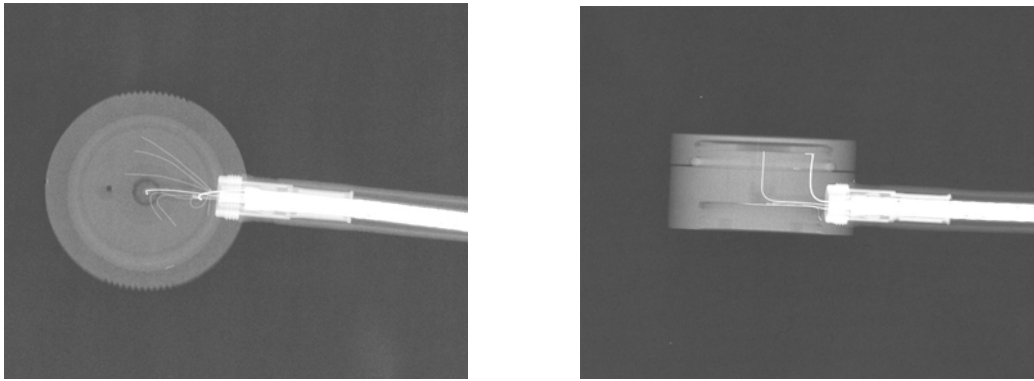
Radiographs of an Advanced Markus type ionisation chamber
